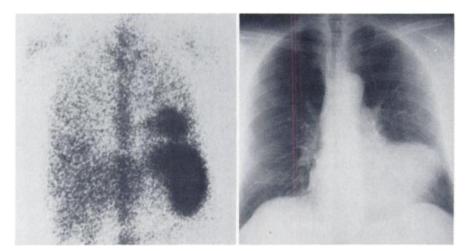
Anterior view of thorax and abdomen, obtained with 800 μCi In-111 WBCs (left). Intense accumulation appeared in chest above spleen, and was initially throught to be pneumonia before examination of patient's chest radiograph. Six mCi of Ga-67 citrate was injected i.v. immediately after this scan because of complaints of left shoulder pain and concern for osteomyelitis not seen on this study. PA chest radiograph (right) demonstrates cardiac enlargement with grossly abnormal left-ventricular border highly suggestive of LV aneurysm. No pulmonary infiltrates are present, thus making pneumonia unlikely. Left hemidiaphragm is normal in position, making subdiaphramatic location for In-111 WBCs unlikely. Infected mural thrombus and/or aneurysm was suspected at this time.
